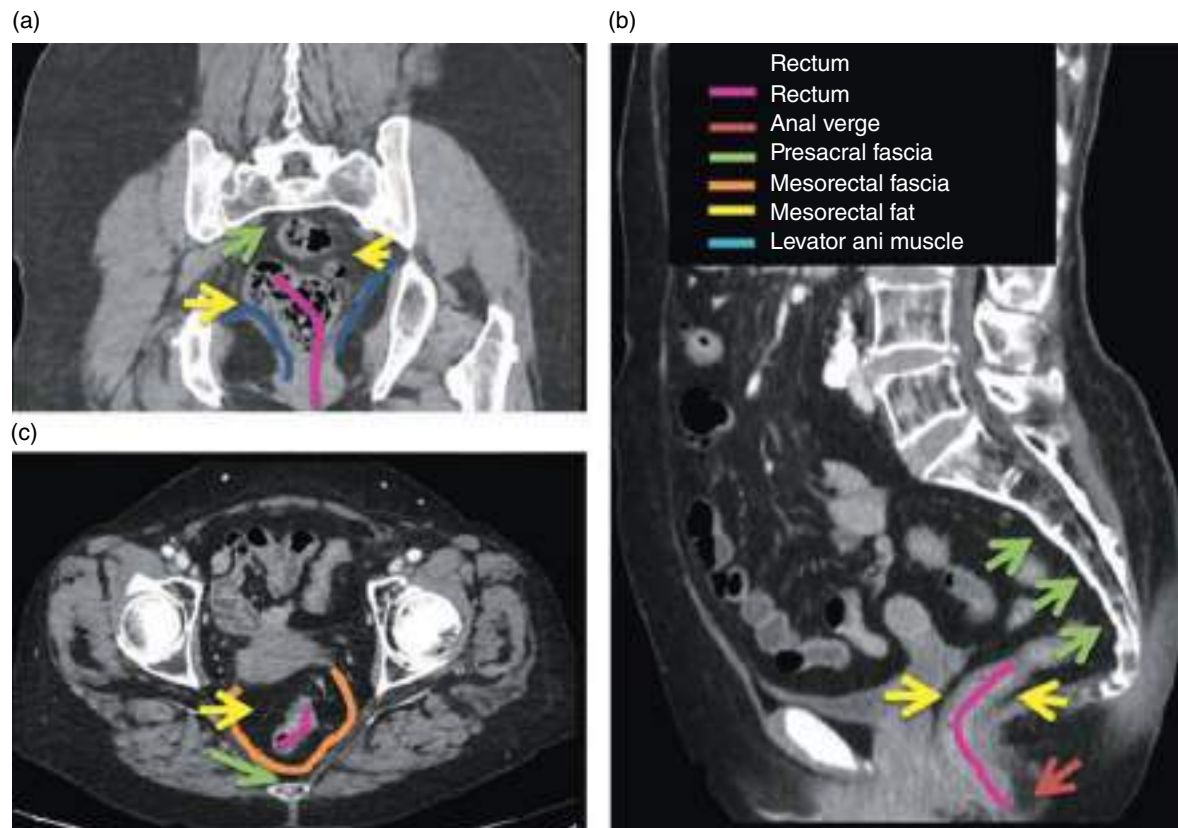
Rectum. (a) Coronal noncontrast MPR CT image (portal venous phase). (b) Axial contrast-enhanced CT image (portal venous phase). (c) Sagittal contrast-enhanced MPR CT image (portal venous phase).
